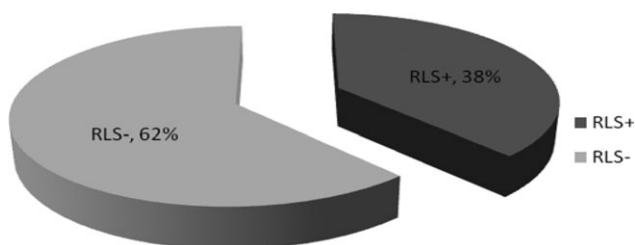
Incidence of a right-to-left shunt by transcranial doppler in congenital heart disease patients with no known cardiac shunt.
